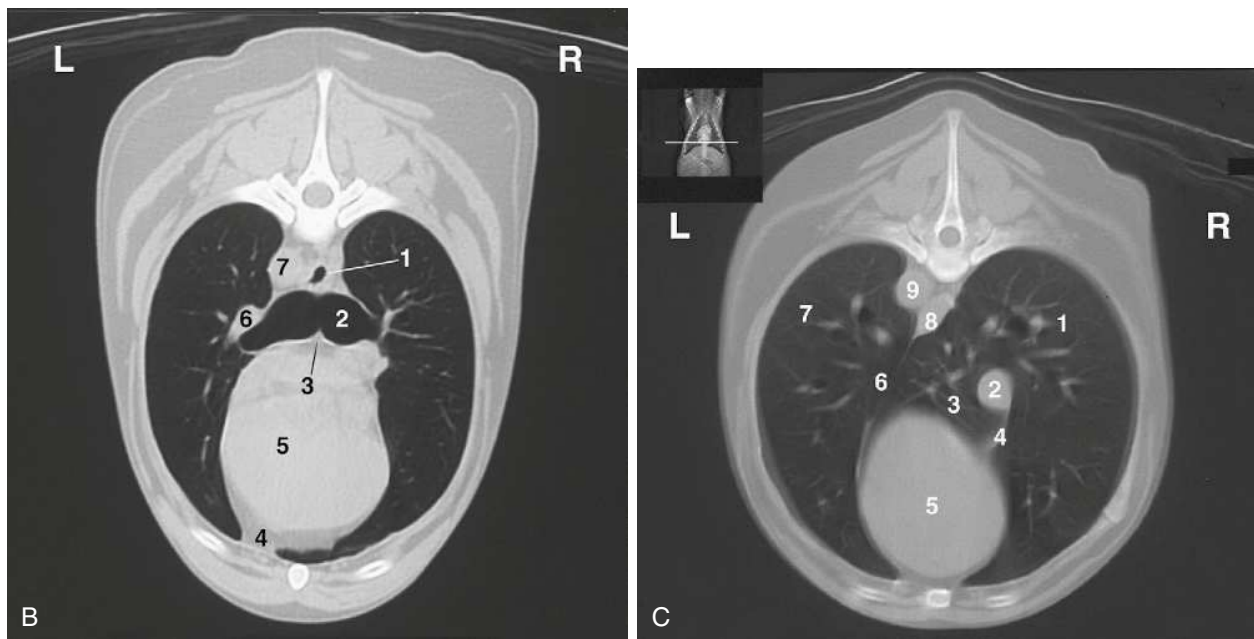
cont'd B, CT image, cranial thorax.
